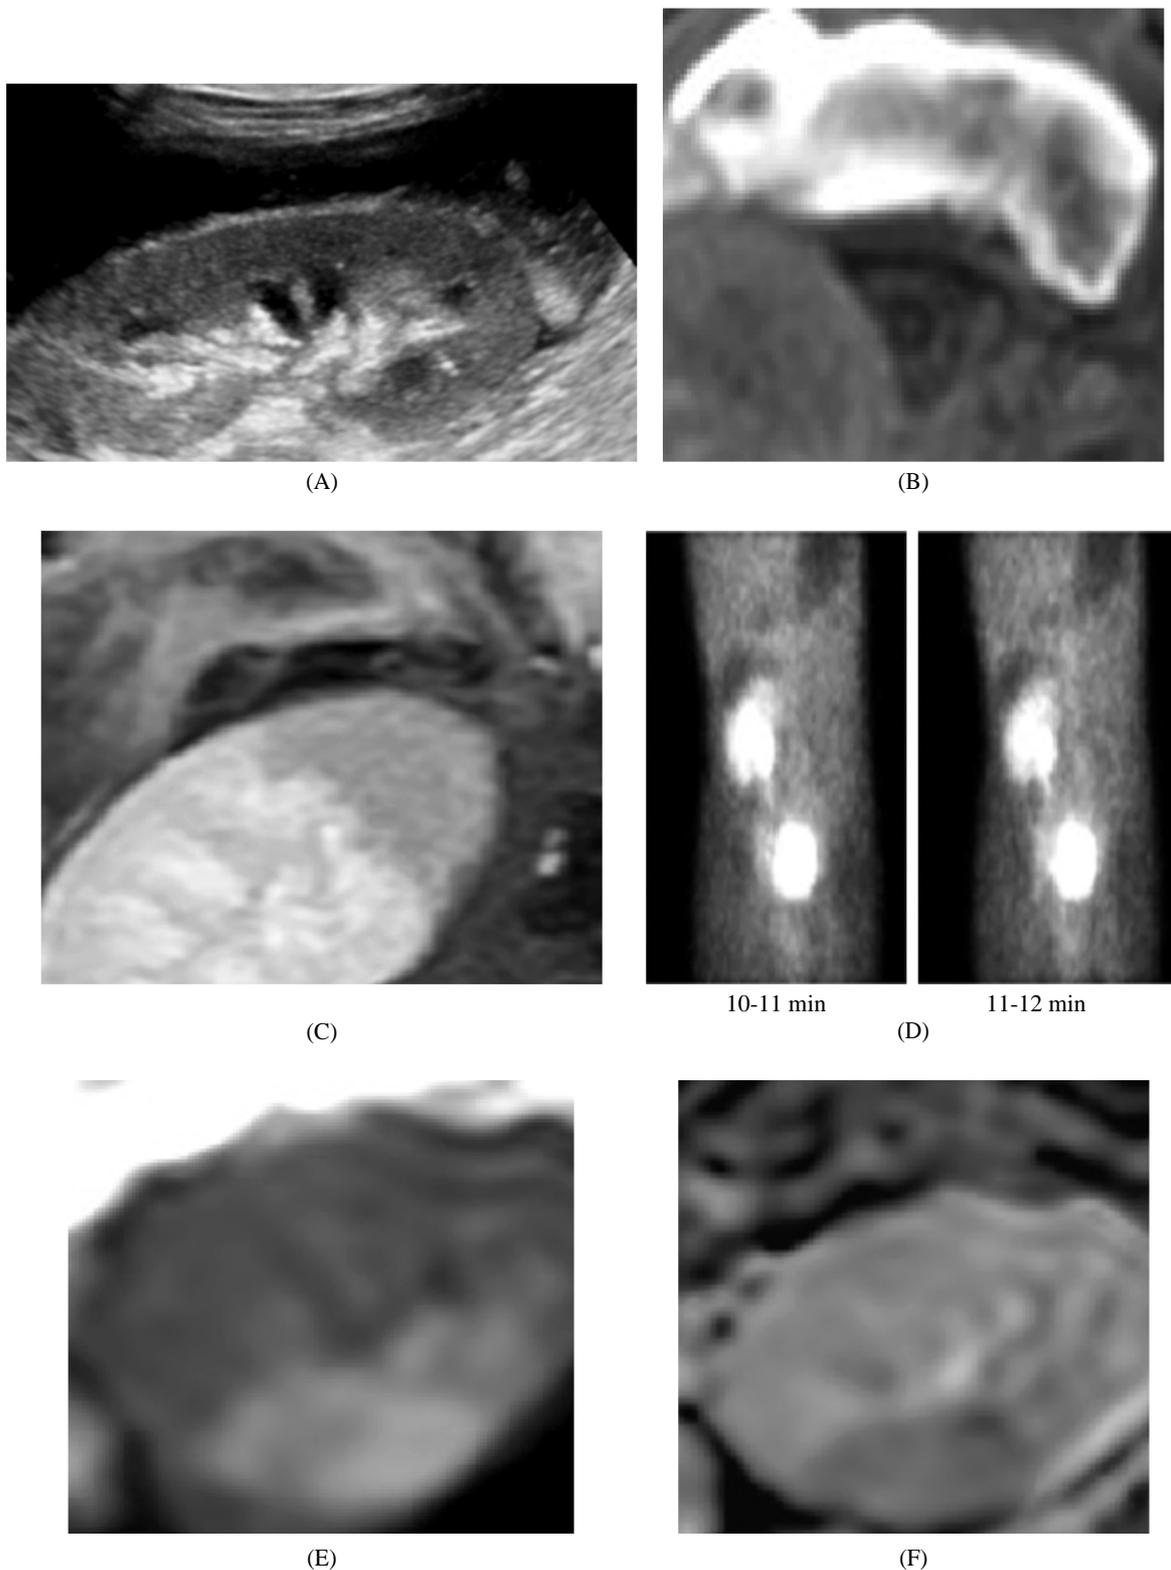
A 35-year-old female patient presented with swelling at right iliac fossa related to the graft. Routine US showed well defined heterogenous peri- graft fluid collection. That diagnosed as perinephric hematoma by MRI (high SI at T 1 WI), with upper polar infarct by (post contrast MRI, and Renogram), as incidental finding. The case underwent PCD fixation with aspiration of blood. (A): Grey scale US shows perinephric collection. (B): Axial T 1 -W fast SE MR image shows the pronounced perinephric collection with heterogeneous high SI compared with renal parenchyma. (C): Post contrast T 1 WI corticomedullary phase shows marginal enhancement of the collection with hypo-perfused upper polar region that reported as cortical infarction. Which in turn seen restricted at DWI (E) and low ADC map (F). (D): Diuretic renography shows perinephric photogenic area related to upper pole that reported as a collection associated with upper hypo perfused area.
